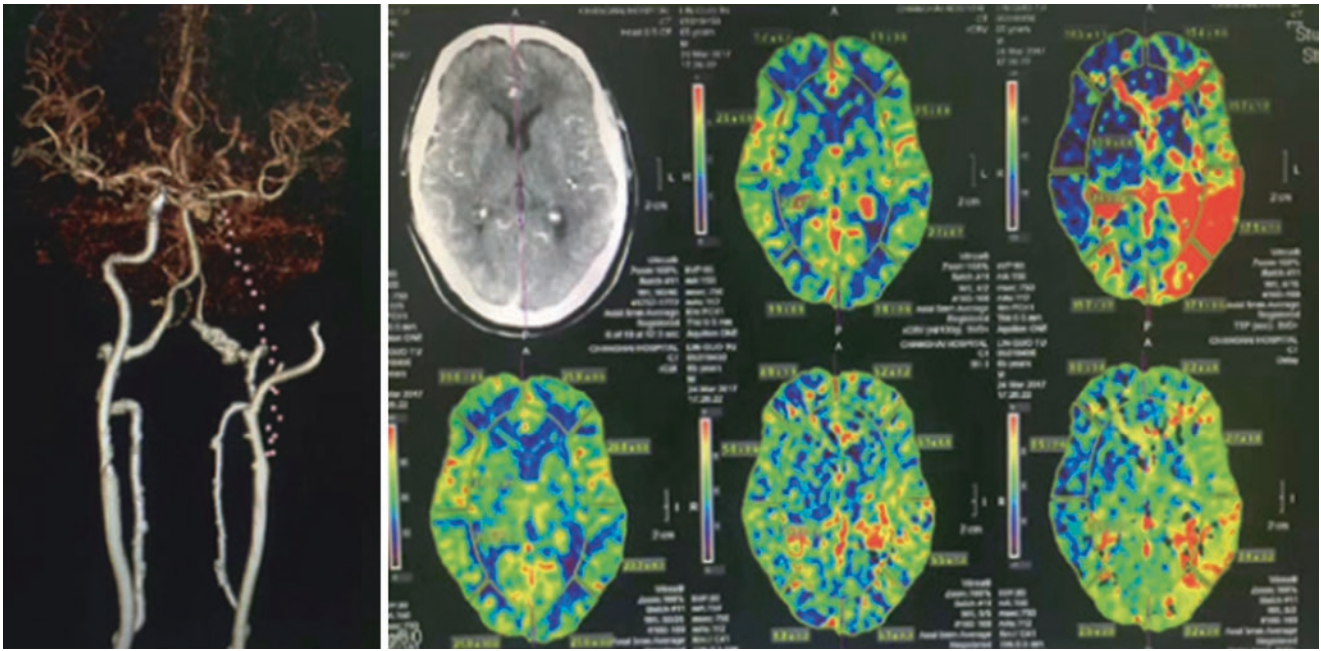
Preoperative CTA and CTP examination
